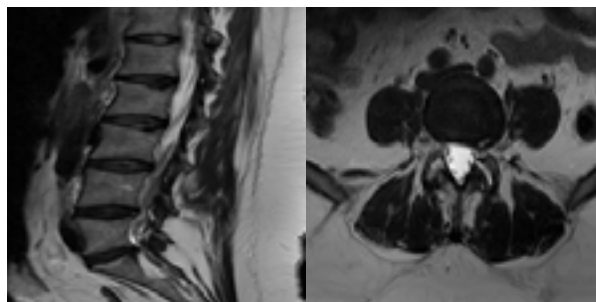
MRI lumbar spine T2 sagittal and axial view of the same patient after one year with conservative treatment shows reduction of both L4- and L5 disc prolapse.
